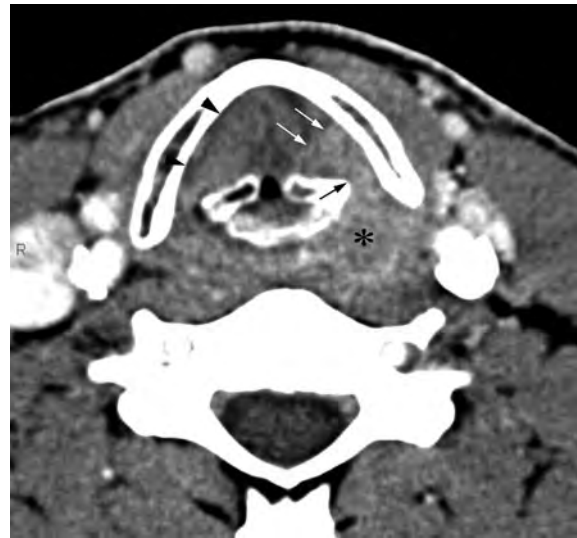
Axial contrast-enhanced CT image through the true vocal cord level demonstrates a large pyriform sinus cancer on the *left* (*asterisks*) that is extending in submucosal fashion into the left true vocal cord (*white arrows*). The extension into the true vocal cord is slightly higher in density than the normal vocal cord tissues; also slight widening of the distance between the arytenoid and thyroid cartilage (*black arrow*), the disorganization of the intrinsic vocal cord musculature and the obliteration of the paraglottic fat plane provide additional clues to the glottic extent of the primary tumor. Note that the normal paraglottic fat plane (*arrowheads* on *right*) at the true vocal cord level are significantly more difficult to delineate than at the false vocal cord level (compare with Fig. 9)
